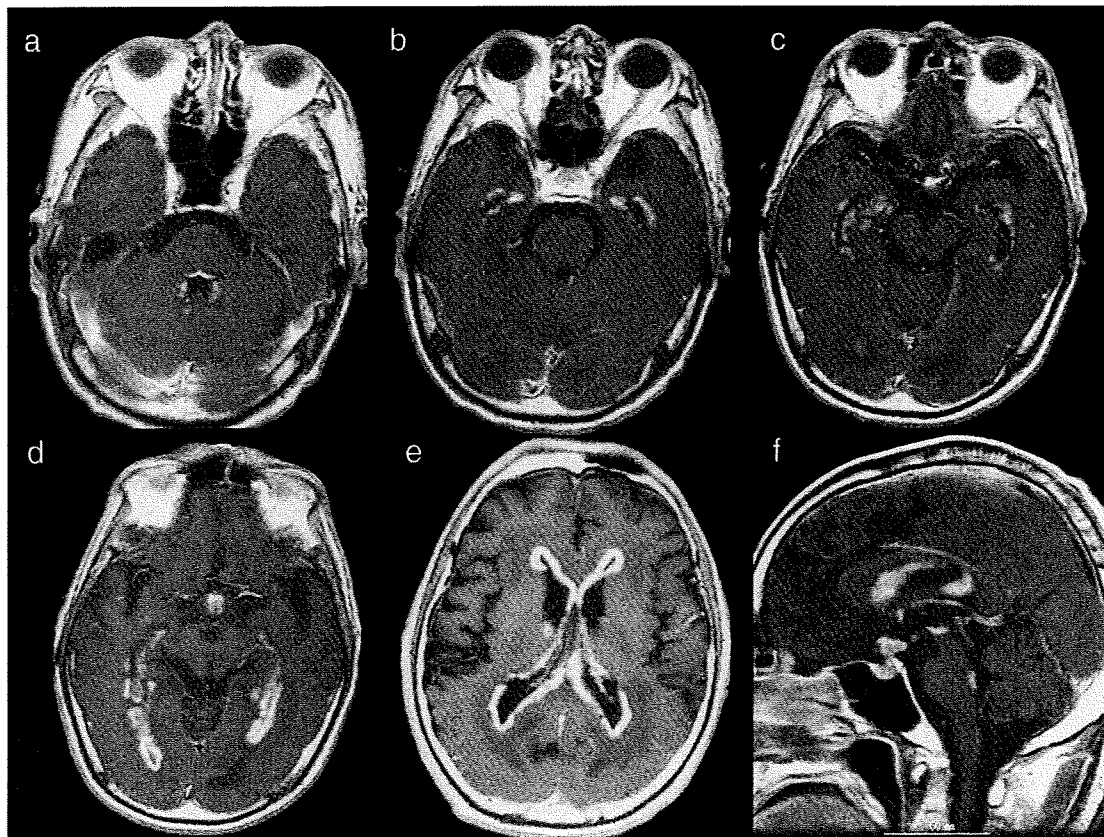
Gadolinium-enhanced T1-weighted image disclosed abnormal enhancement around the lateral ventricle, third ventricle, fourth ventricle, and pituitary gland. Low intensity areas were also seen at the periventricular parenchyma, suggesting edema.
